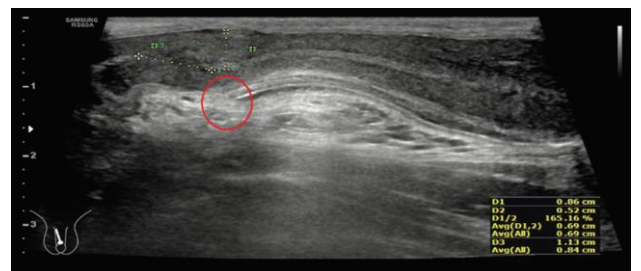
Ultrasonography of the penis: Focal discontinuity of proximal tunica albuginea is pointed by the red circle.
